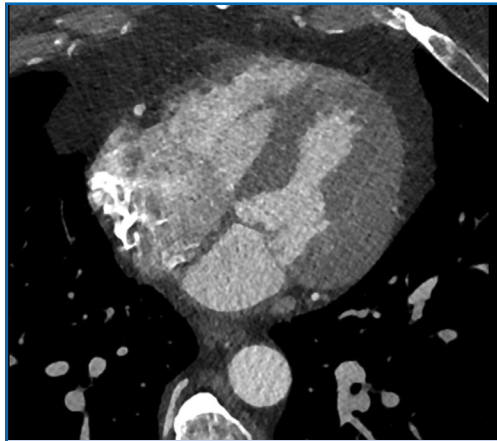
Computed tomography cardiac angiogram; nodular thickening identified at anterior mitral leaflet.
